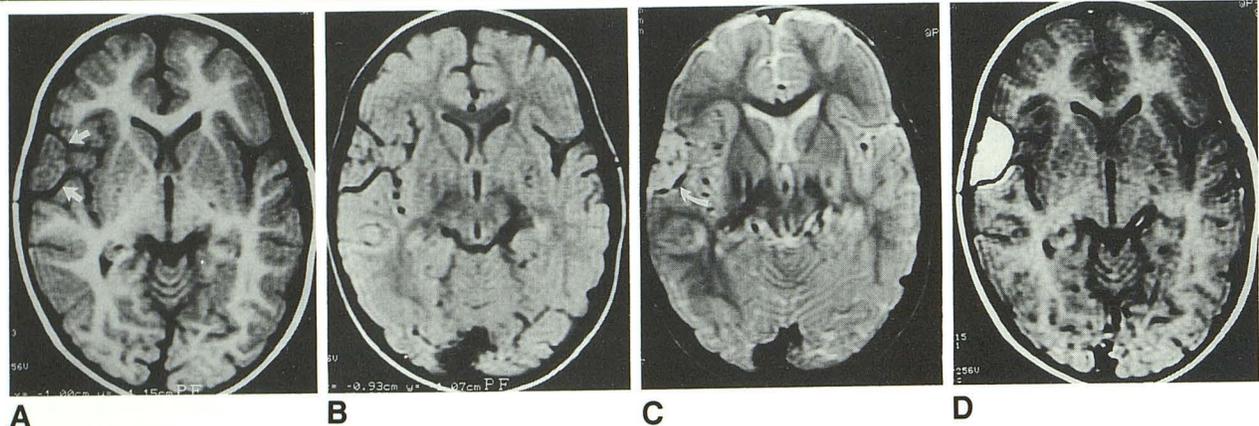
MR imaging of the head, 0.5 T.
